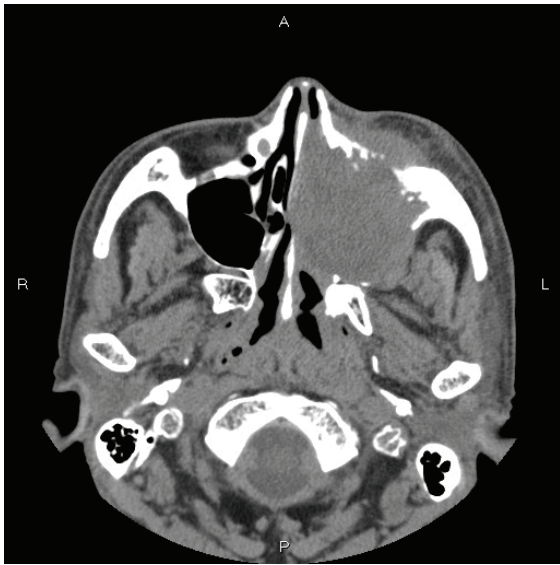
CT findings. The left maxillary sinus shows infiltrative tumor. Nasal cavity is also involved.
